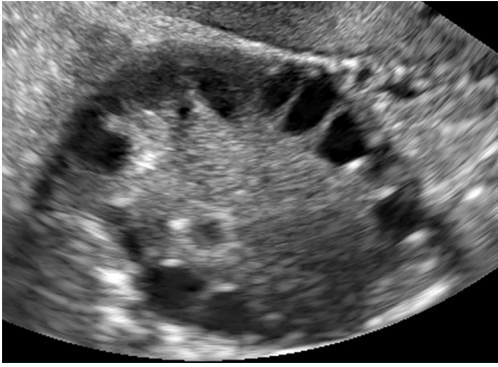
B-mode ultrasound of polycystic ovary.
